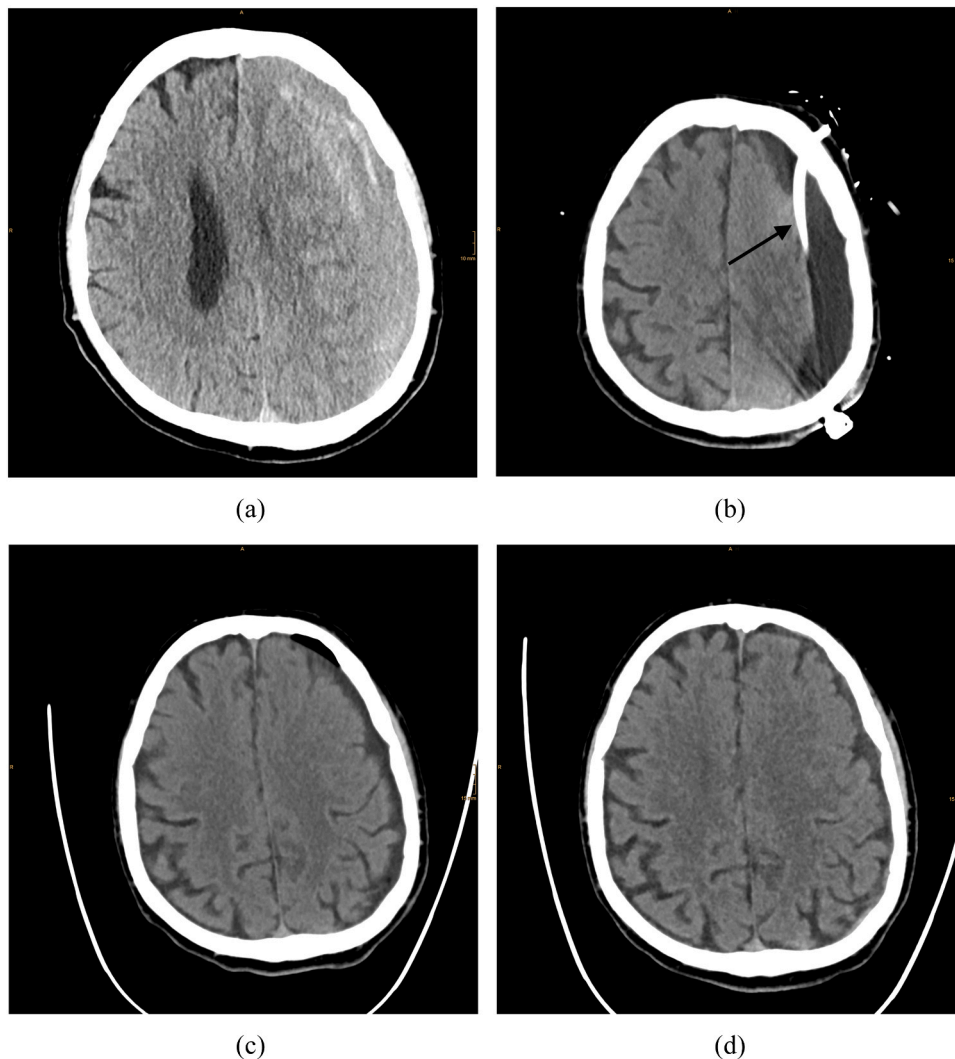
A-D Radiological course of a 68-year-old male patient treated with TDC-FIT. A. A 68-year-old male with a left-sided membranous cSDH presented to the emergency department with right-sided hemiparesis. B. TDC-FIT was performed with a 9 Fr dual-lumen catheter (arrow). At the first radiological follow-up on day 3, the hematoma membranes had completely transformed into a homogenic hypodense subdural fluid collection. Subsequently, the system was changed into a passive drainage. After outflow suspension the drainage was removed. C. A CT scan before discharge on day 4 showed a regress of the hematoma and the patient was discharged without neurological deficits. D. Three weeks later, the collection was almost completely resolved. The hemiparesis was no longer present, the patient experienced no complications, and the functional outcome was categorized as mRS 0.
